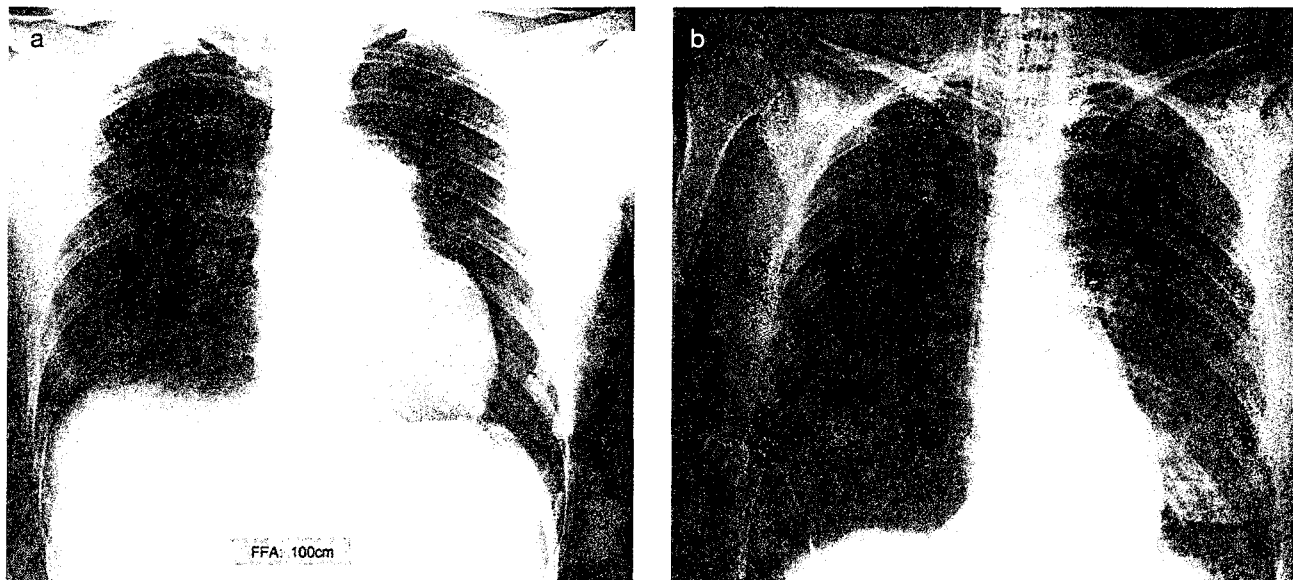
Chest X-ray in a 29-year old female patient with primary pulmonary hypertension before (a) and 2 weeks after (b) left single lung transplantation. The dilated right heart has regained normal radiographic appearance.
